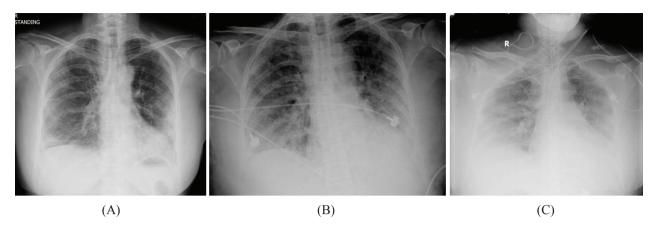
Chest plain film showing (A) infiltration and consolidation in the bilateral lung on day 1; (B) progressive infiltration and consolidation in the bilateral lung on day 3; (C) increasing infiltration, a blunting costodiaphragmatic angle and ground glass at the bilateral lung on day 23.
